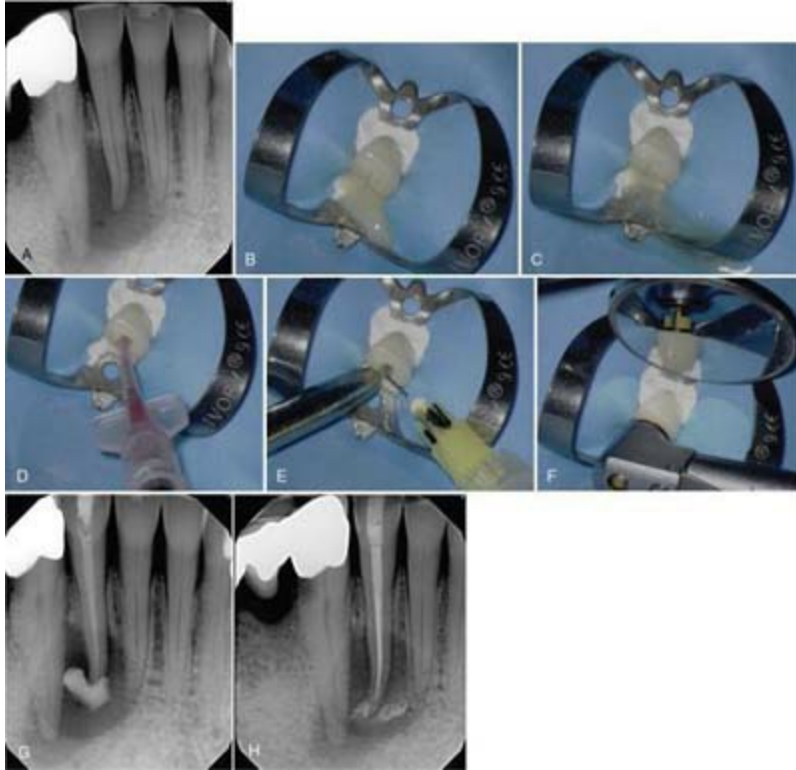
Drainage of pus through the root canal. A, Acute apical abscess arising from the lower right lateral incisor with radiographic radiolucency. B, Initial drainage through the canal. C, Persistent drainage through the canal. D, Aspiration of the content with a plastic suction tip. E, Irrigation with NaOCl. F, Mechanical debridement. G, Placement of calcium hydroxide. H, Obturation of root canals during second visit.
